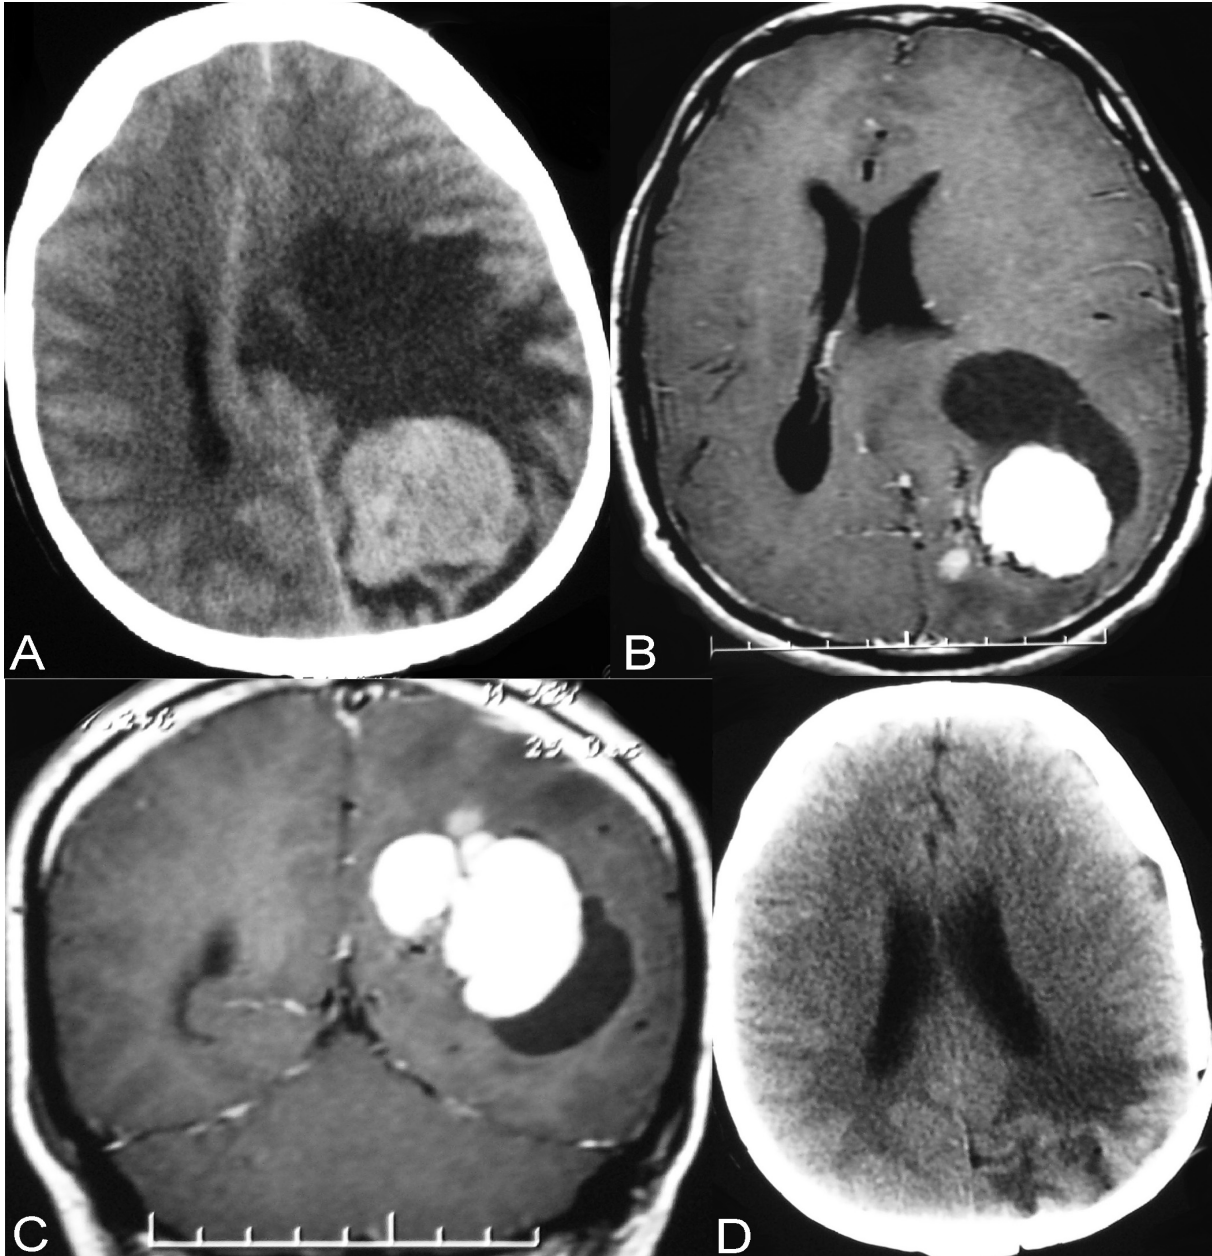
Preoperative contrast enhanced axial CT scan of the cranium (a) showed markedly enhanced tumor with irregular borders. Axial (b) and coronal (c) MR scans demonstrated a cystic component adjacent to the inferolateral portion of the tumor. Postoperative axial CT scan (d) demonstrates complete removal of the cystic mass.
